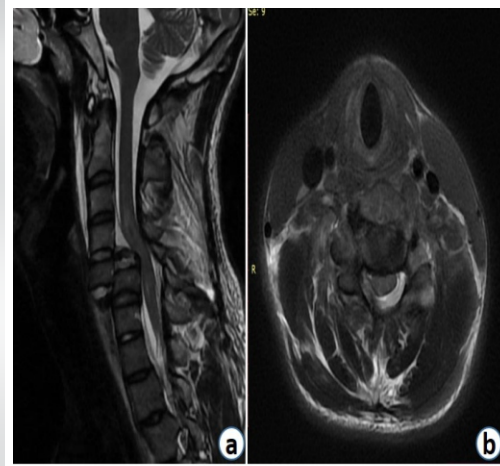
Figure 2: MRI T2 sagittal image (a) and T2 axial limage (b) sequence show a fracture dislocation and kinking of the cord.
